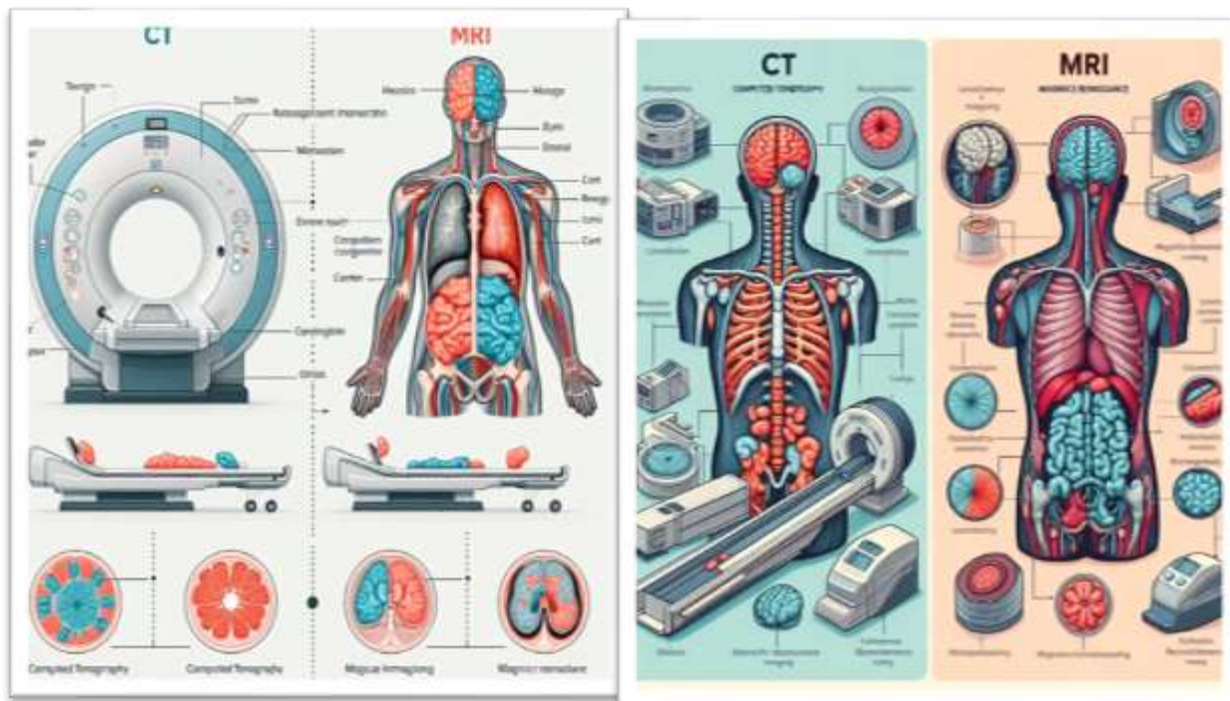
showing the difference between CT and MRI
